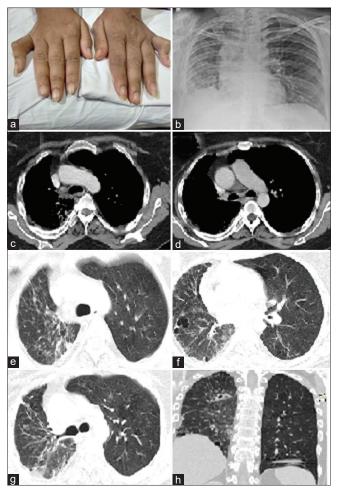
(a) Flexion deformity of the proximal interphalangeal joint of 5th fingers bilaterally. (b). Chest X-ray showing volume reduction of the right lung with mediastinal shift toward the right. (c and d) Mediastinal windows of computed tomography scan showing the absence of right main pulmonary artery. (e-h) High-resolution computed tomography scan showing foci of ground-glass opacity, cystic changes, and septal thickening in the right lower lobe with volume loss
